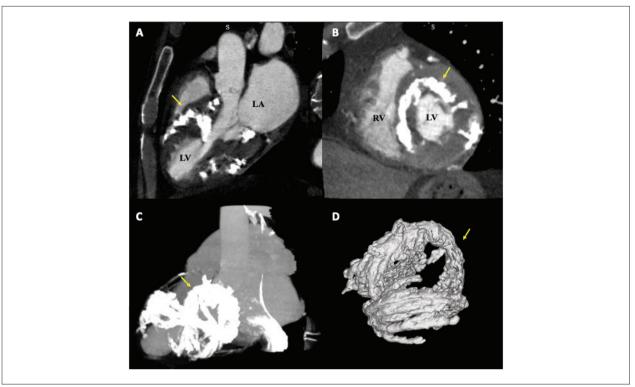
Computed tomography angiography (CTA) shows extensive intramyocardial calcification (A and B). CTA volumetric reconstruction shows extensive calcification with Torrent Guasp pattern (C and D). The yellow markers highlight calcium distribution. LA: left atrium; LV: left ventricle; RV: right ventricle.
